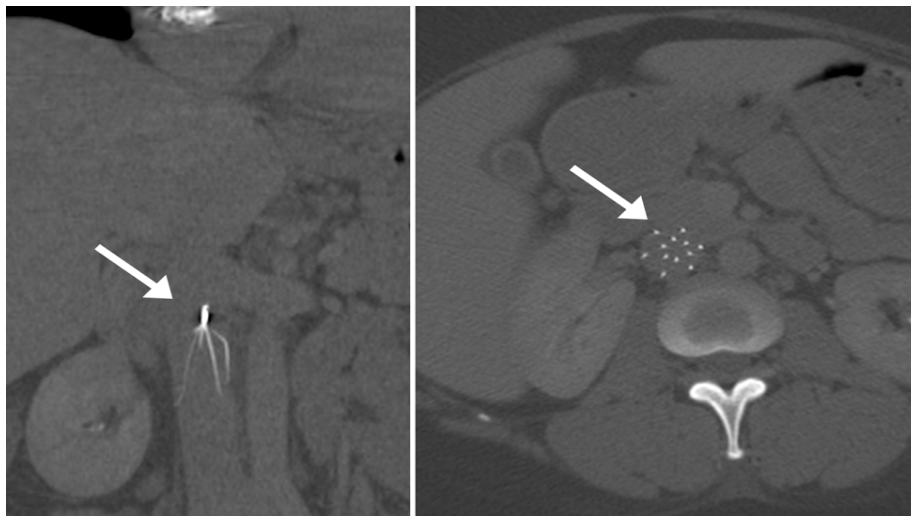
CT scan of the abdomen showing IVC filter (arrow) in place.
